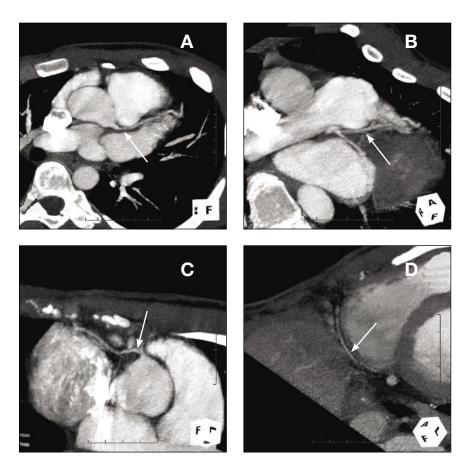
Computed tomographic angiogram at one-month follow-up, showing (A) a normal proximal left anterior descending artery, (B) a normal left anterior descending coronary artery, (C) a normal proximal right coronary artery, and (D) a normal right coronary artery in a 20-year-old man who presented with Kawasaki disease.
